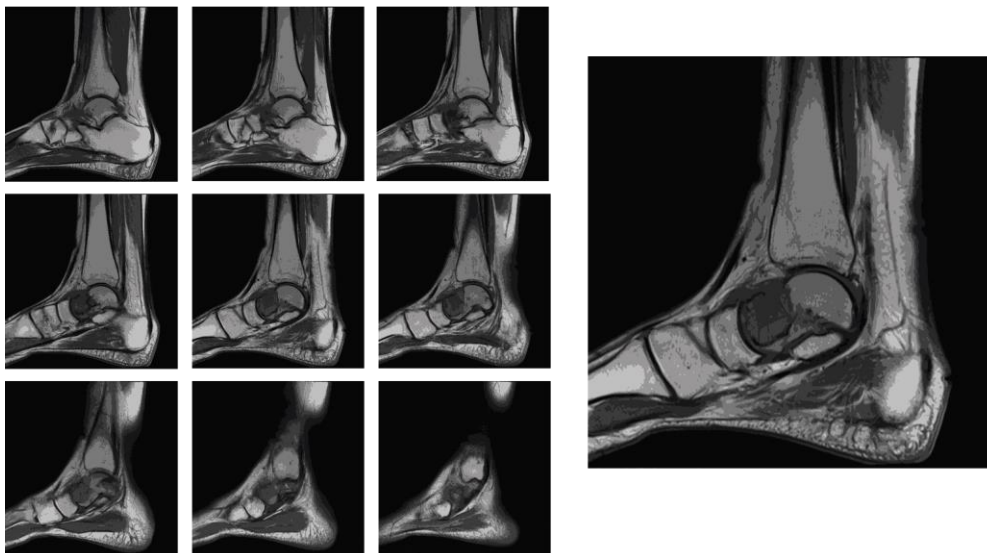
Right Ankle MRI T1W Sagittal View.
